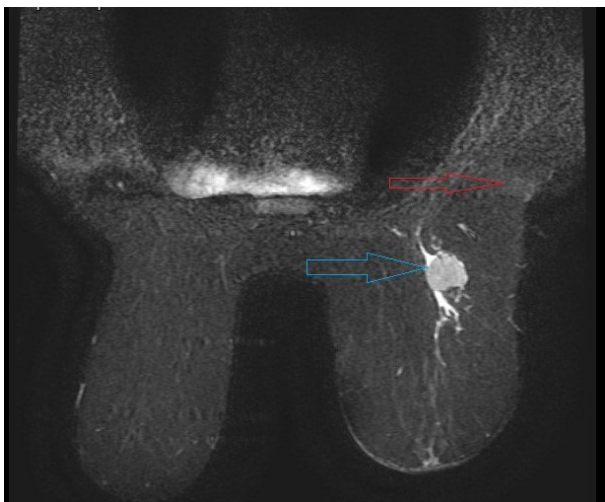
Magnetic resonance imaging (MRI) image of Case 1. Blue arrow: Type 3 pattern breast mass. Red arrow: suspicious axillary lymphadenopathy.
